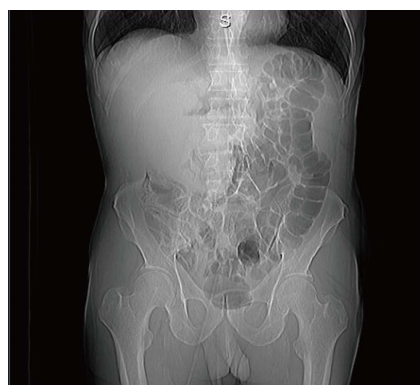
Abdominal radiography showing right upper quadrant mass enlargement.
